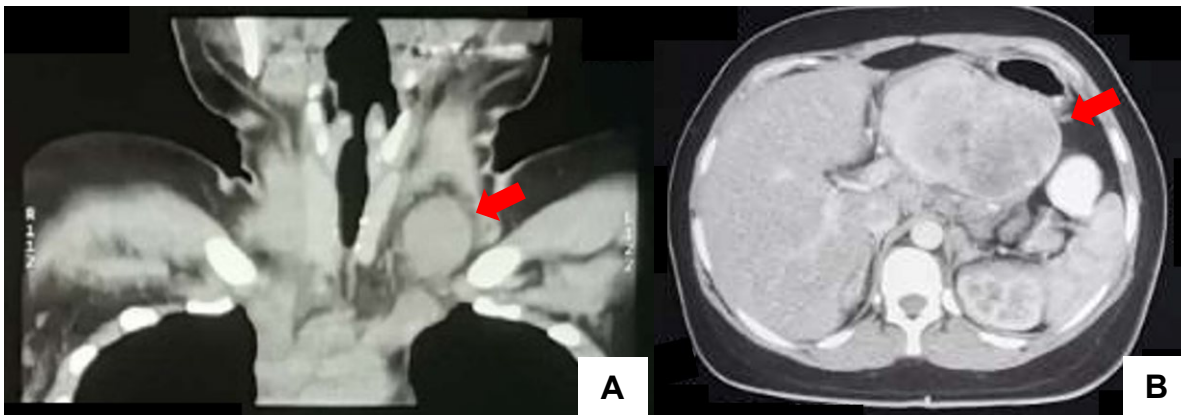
(A) CT scan of neck showed soft tissue mass (red arrow) in the region of the left carotid space with minimal fat stranding. (B) CT scan of the abdomen showed heterogeneously enhancing hypodense focus (red arrow) seen in the left subhepatic area closely adherent to the left lobe, pancreatic body and tail and lesser curvature of the stomach.
